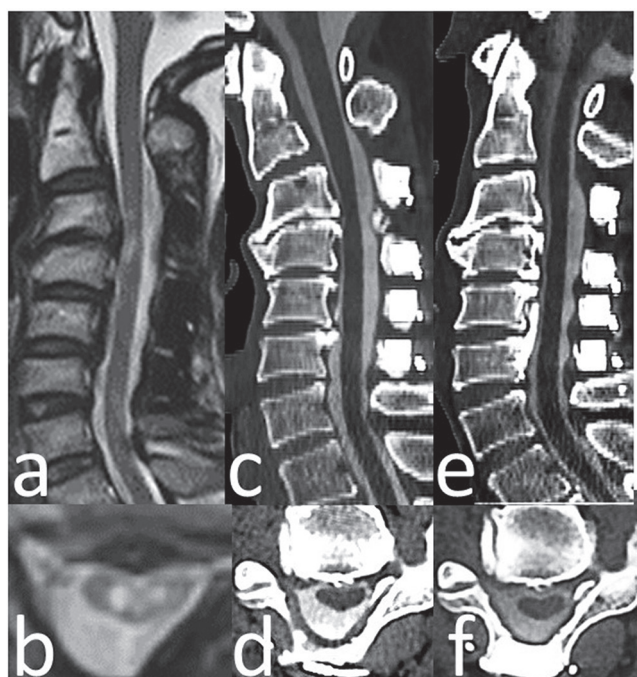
Sagittal (a) and axial (b) magnetic resonance images at 14 years after expanding laminoplasty showing swan neck deformity and round intramedullary high-signal intensity of the cervical spine with compression myelopathy. Sagittal (c, e) and axial (d, f) computed tomography myelograms showing C2–3 instability. The spinal cord was compressed by the C3–4 soft and hard disc, especially on flexion (c, d) compared to extension (e, f).
